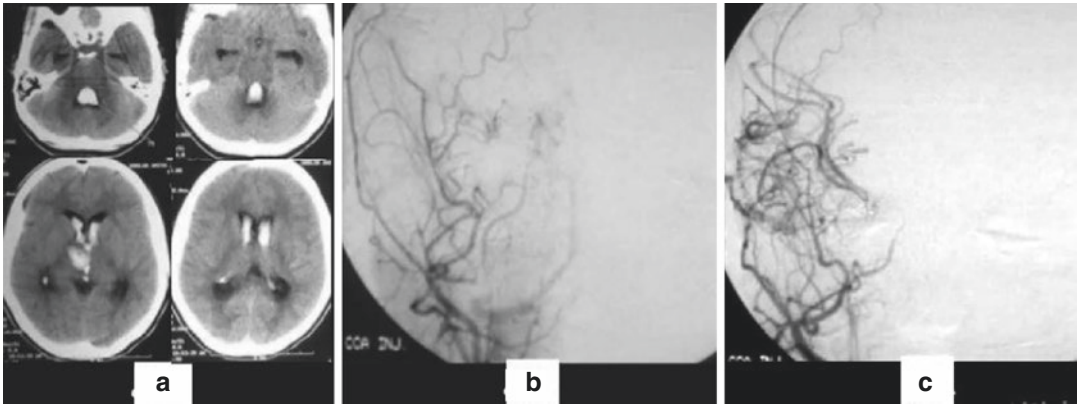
(a) Shows CT Brain plain with intraventricular hemorrhage. (b) DSA with a puff of smoke appearance. (c) postop DSA with STMC anastomosis
